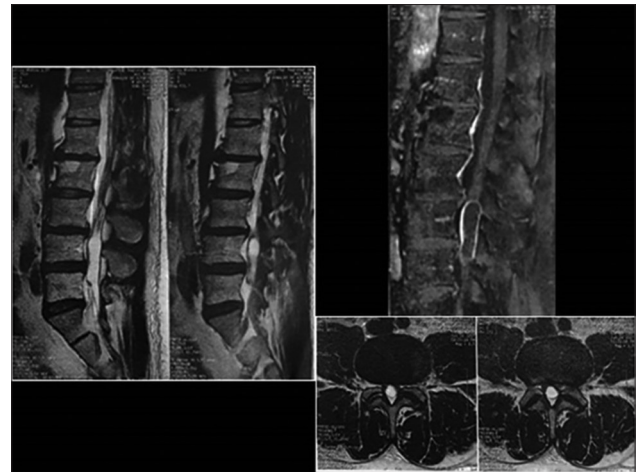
Cystic lesion with peripheral enhancement at L4-L5 level - caudal migration (2017 july MRI)
